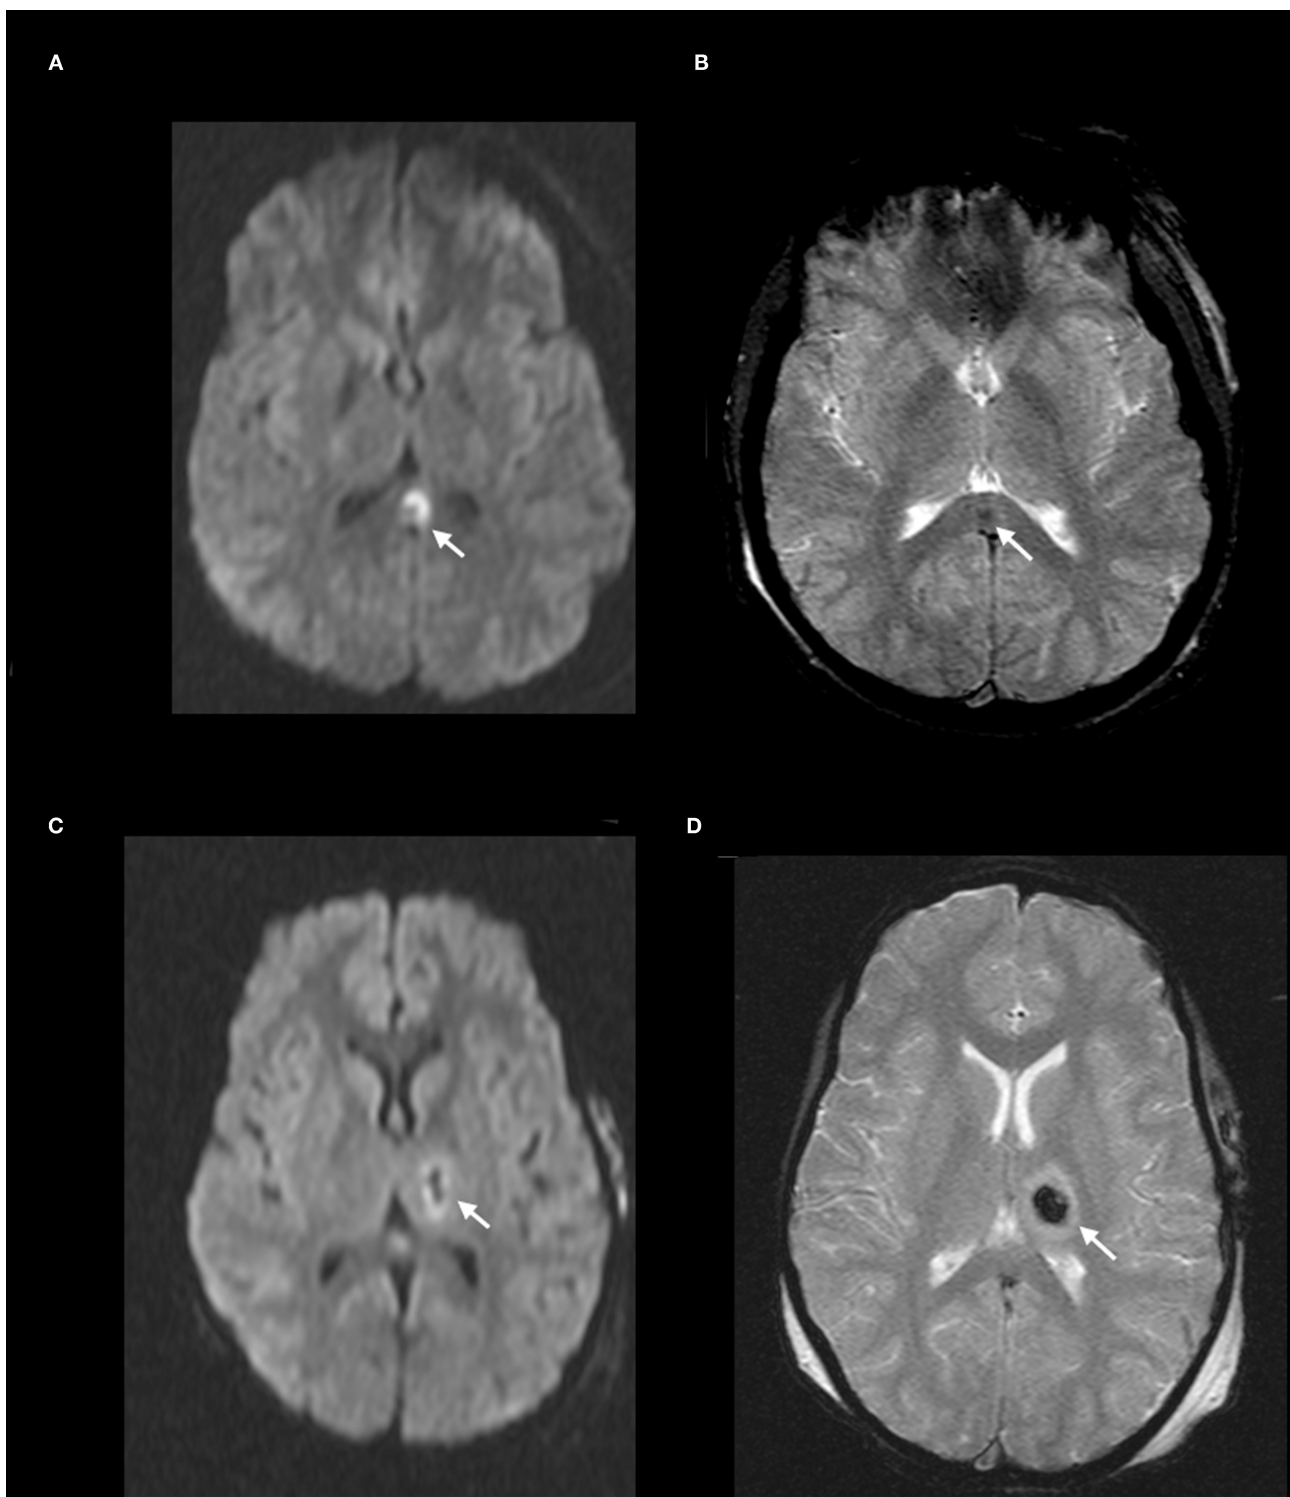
DAI Zone 2 (Deep) MRI Findings. (A) axial diffusion weighted (DWI) and (B) axial T2* weighted sequences show a focus of restricted diffusion (A, white arrow) at the midline splenium of the corpus callosum with associated susceptibility effect (B, white arrow). (C) axial DWI and (D) axial T2* weighted from a different severe pediatric TBI patient with restricted diffusion (C, white arrow) and associated susceptibility effect (D, white arrow) in the left thalamus.
